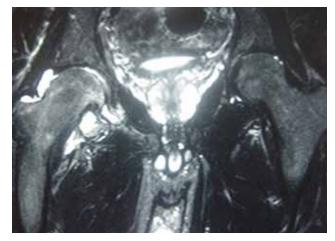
Fat-suppression coronal magnetic resonance imaging of pelvis. Note hyperintensity signal of intra-articular effusion.
